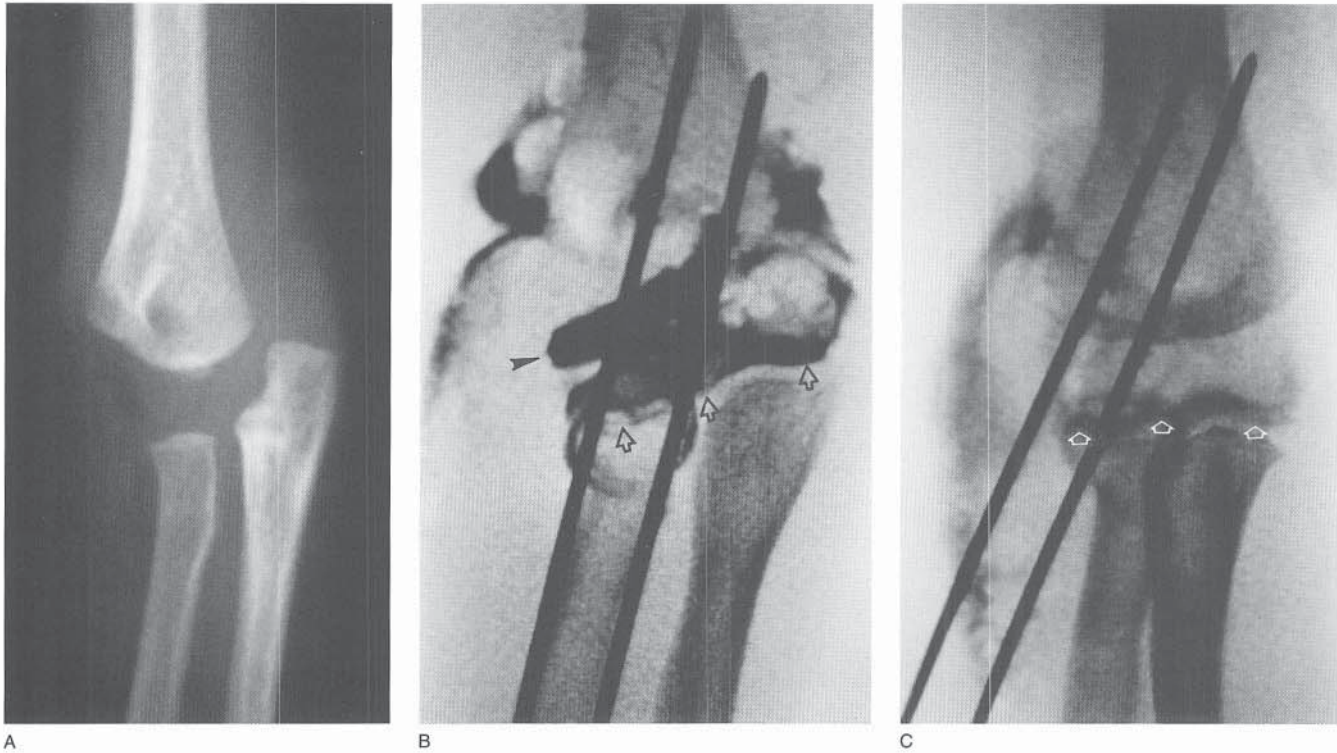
A, AP radiograph of transphyseal separation of the distal humerus. The radius and capitellum remain congruent despite the medial translation of the forearm. B, Arthrogram obtained after an initial attempt at closed reduction and pinning. Note the varus alignment of the joint surface (*open arrows*) and the dye spreading laterally between the metaphysis and the distal fragment (*arrowhead*). C, Arthrogram obtained after remanipulation. The joint surface is now anatomically reduced (*open white arrows*).
